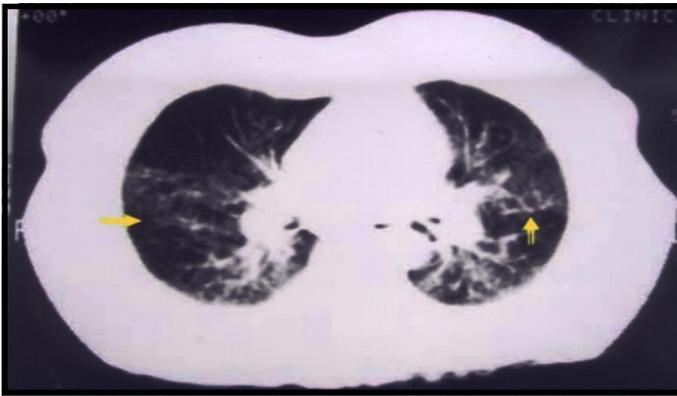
Computed tomography chest - nodular and diffuse reticular infiltrates most prominent in the midfields and basally, marked by arrows.
